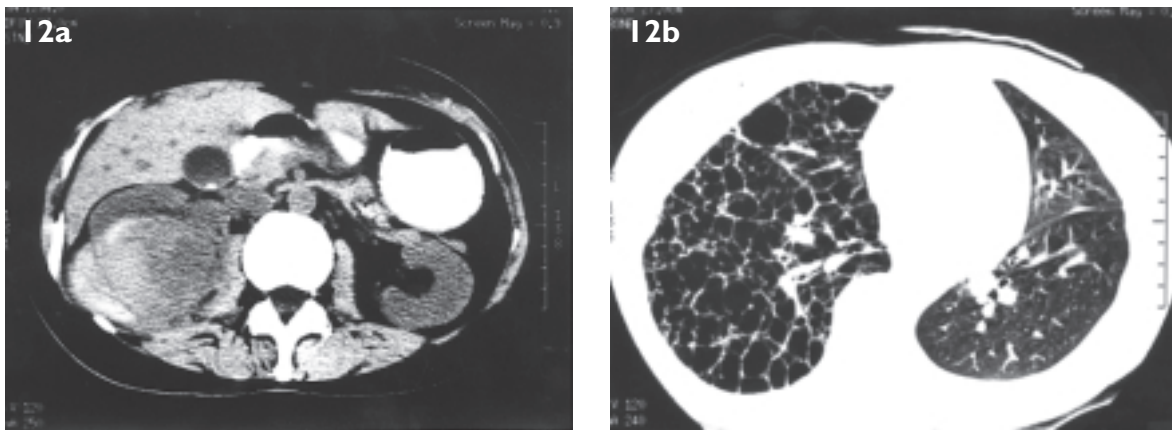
Haemorrhagic involvement of the psoas muscle in a 29-year-old woman with lymphangiomyomatosis and spontaneous rupture of a right renal angiomyolipoma (not shown). (a) Unenhanced CT scan of the kidneys shows high attenuation areas of fresh haemorrhage within the right perinephric space that involves the right psoas muscle. (b) High-resolution CT scan of the lungs shows multiple well-defined thin-walled cysts in the right lung. Left lung transplantation had previously been performed.
